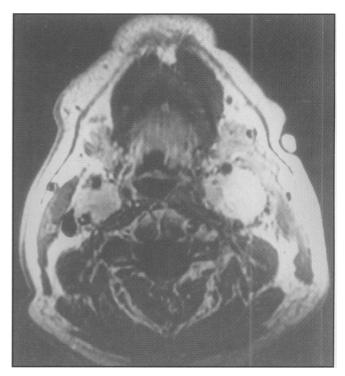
Axial T1-weighted image at the same level following intravenous gadolinium-DTPA.
